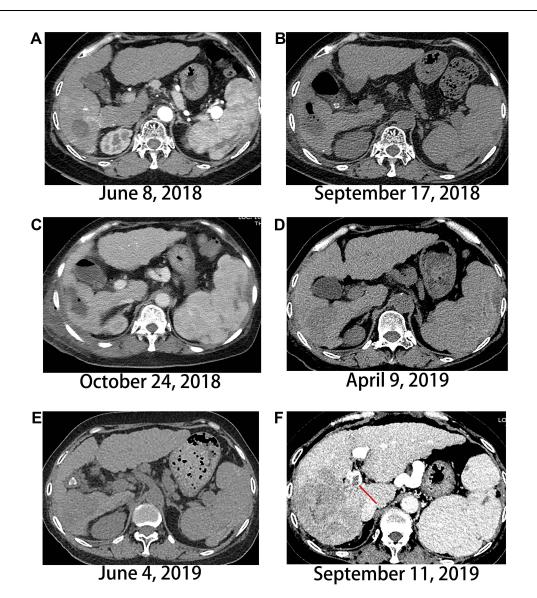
Evolution of the primary liver lesion on computed tomography. (A) Liver lesion in Segment 6 at admission, (B and C) Changes in the segment 6 lesion postmicrowave irradiation, (D and E) The tumor continually progresses. (F) Main portal vein tumor thrombus emerges. Red arrow indicates main portal vein tumor thrombus.
